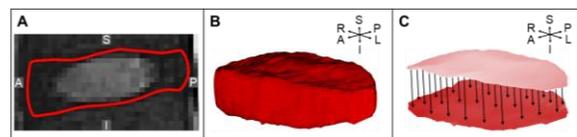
A. Segmentations for each MR image slice were combined and converted into B. 3D models of the IVD. C. Mean IVD height was calculated as the average distance between uniformly sampled points on the inferior (I) and superior (S) surfaces. A=anterior, P=posterior, L=left, R=right
